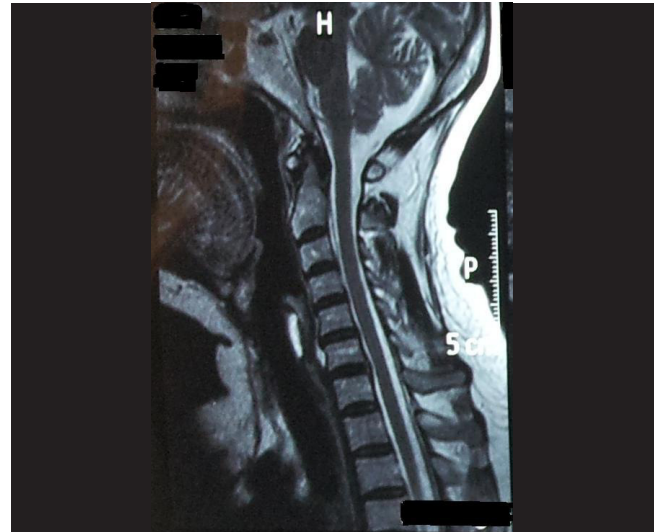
Second magnetic resonance imaging study showed regression of the disc herniation.
